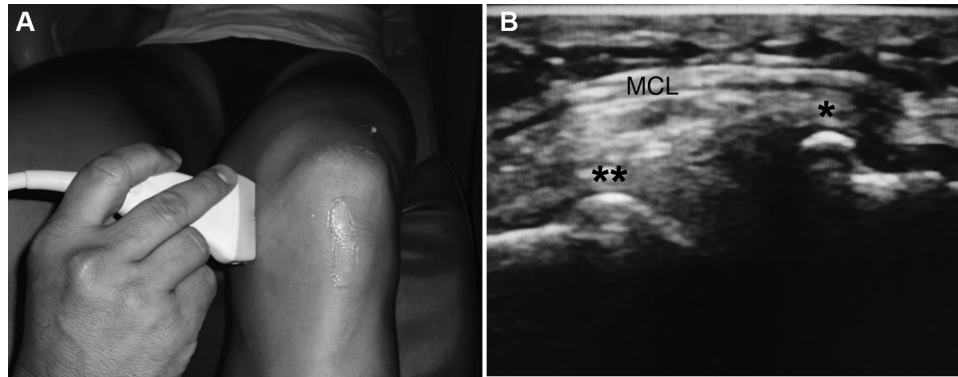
Medial knee sonographic assessment and probe position. (A) Probe position in the medial compartment. The knee rests at 30° of flexion on a prefabricated wedge foam. (B) Ultrasound of the medial compartment in a soccer player with osteoarthritis. Osteophytes of the tibial (*) and femoral () sides of the medial compartment, defined as cortical protrusions of the articular margin. [AQ: 4]
